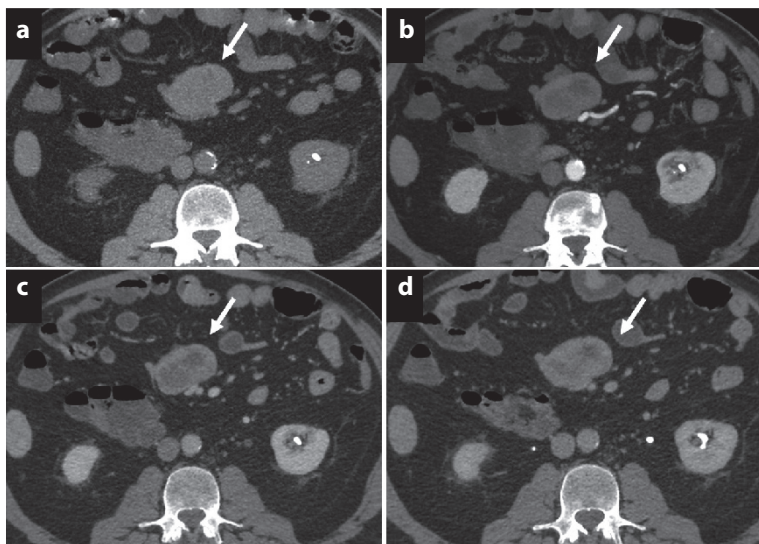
A 63-year-old man with a history of subocclusion. (a) Axial unenhanced CT scan shows a rounded isoattenuating mass in the ileum (*arrow*). The axial arterial (b), portal (c) and delayed (d) phases show progressive centripetal enhancement (*arrows*), an atypical presentation of GE-NETs
